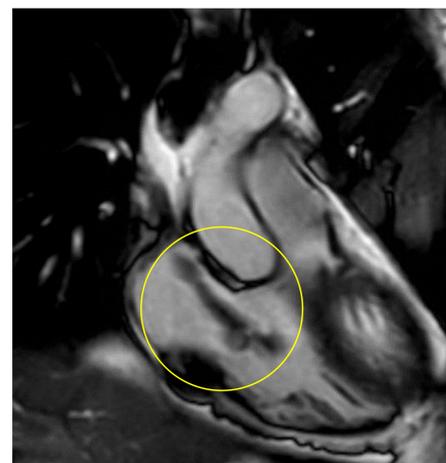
POCUS prompts cardiac MRI, which identifies intracardiac thrombus in the right ventricle
